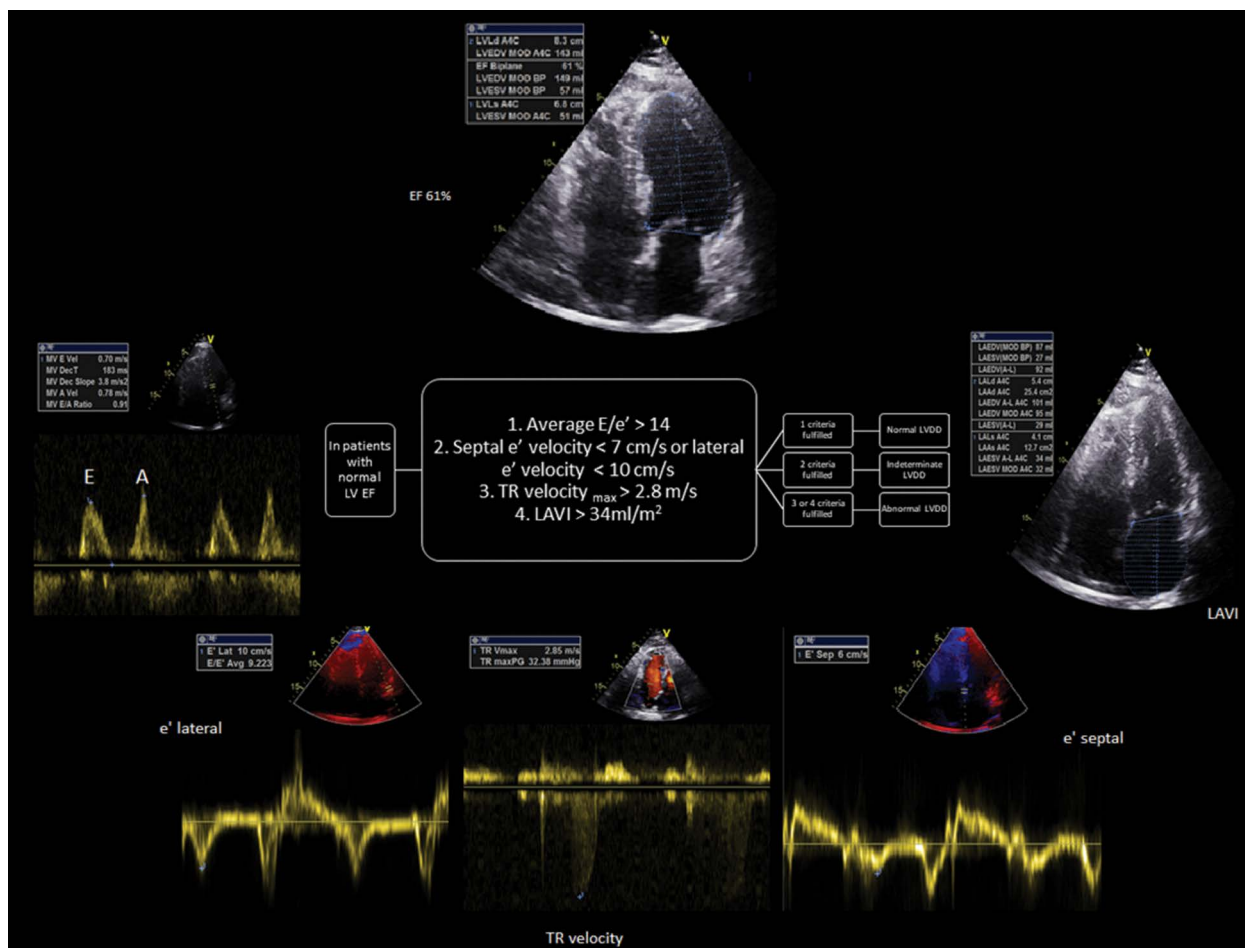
Transthoracic echocardiography images in a patient with the left ventricular diastolic dysfunction concerning European Association of Cardiovascular Imaging/American Society of Echocardiography (EACVI/ASE) 2016 recommendations
